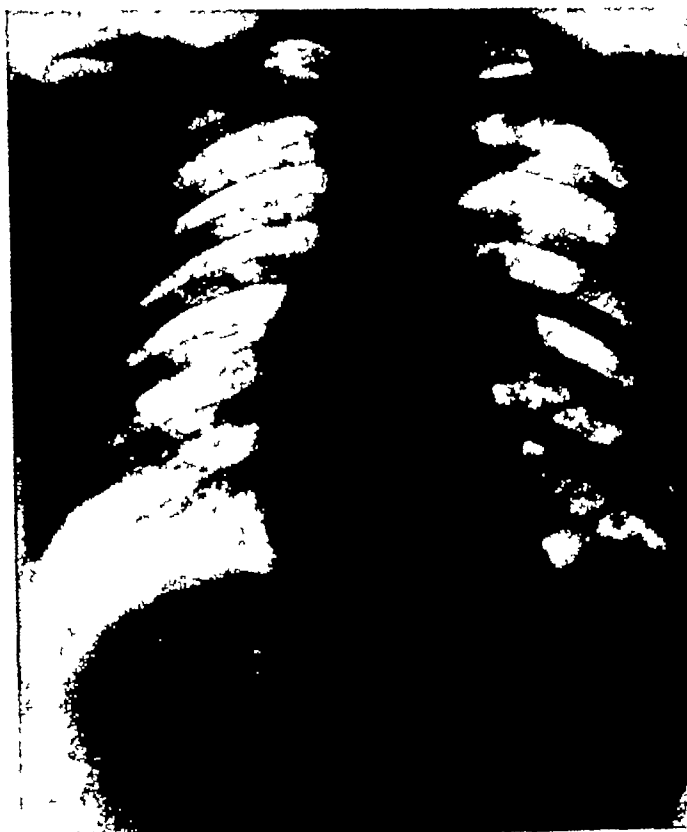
Radiograph of a man of 35 years admitted with an obstructed diaphragmatic hernia (foramen of Bochdalek)
